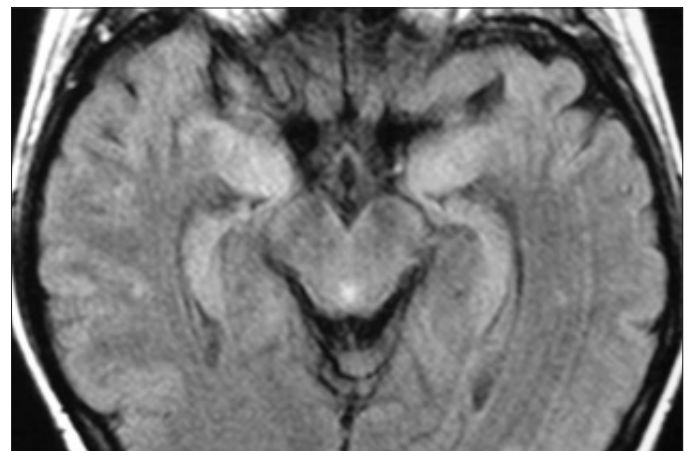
Axial FLAIR image shows increased signal intensity in bilateral hippocampal and parahippocampal areas
